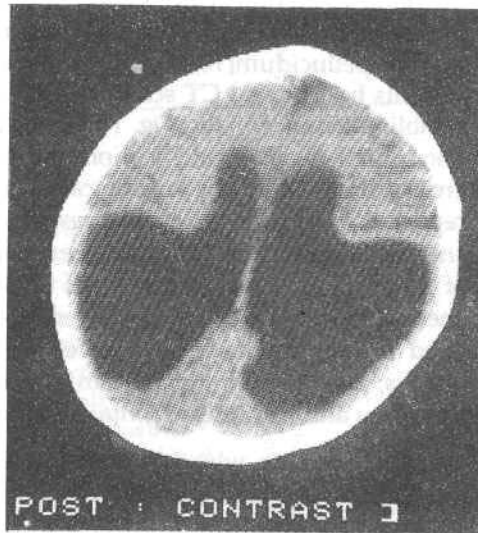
CT scan shows presence of colpocephaly and agyria
